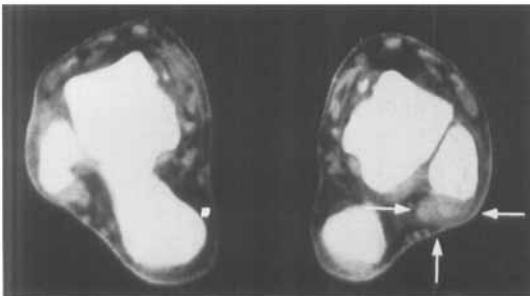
A CT scan showing the swelling of soft tissues around the peroneal tendons (arrows).
